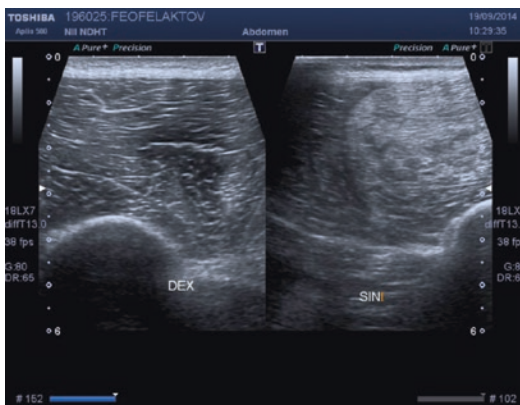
Ultrasound image (normal and muscle contusion)
